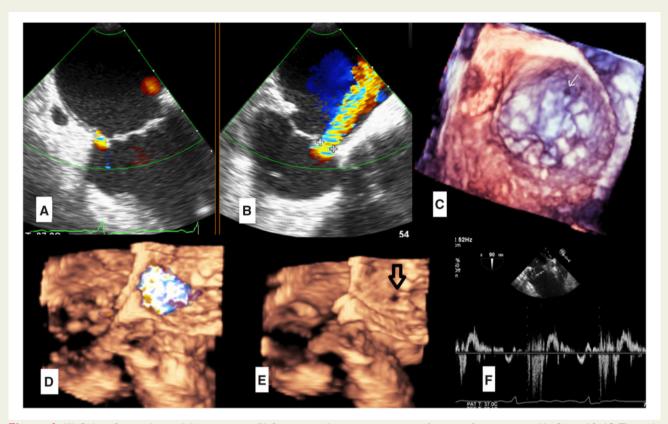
Figure I (*A*) Colour flow at the medial commissure. (*B*) Severe mitral regurgitation at a perforation of anterior mitral leaflet at A3. (*C*) Three-dimensional zoom, the arrow pointed to the perforation at the base of A3. (*D* and *E*) Full volume with and without colour, showed the colour flow and the hole (arrow). (*F*) Pulsed Doppler at left upper pulmonary vein showed systolic reversal indicating severe mitral regurgitation.
